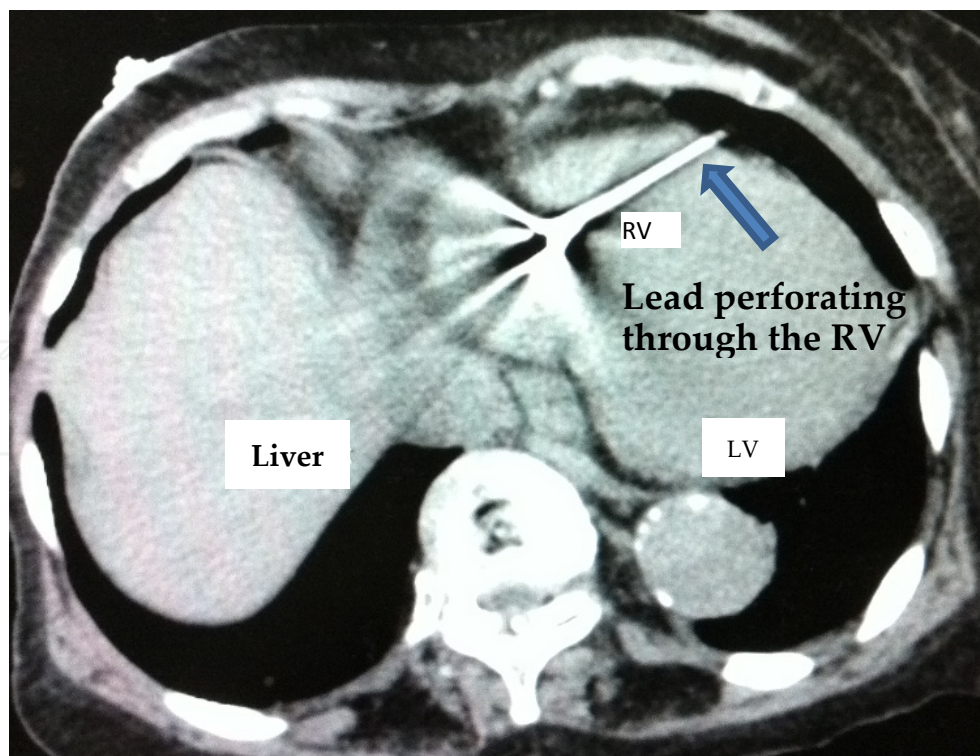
Axial view of CT scan of chest of the same patient in figure 4, showing the RV lead perforation through the RV apex. RV=right ventricle, LV=left ventricle
